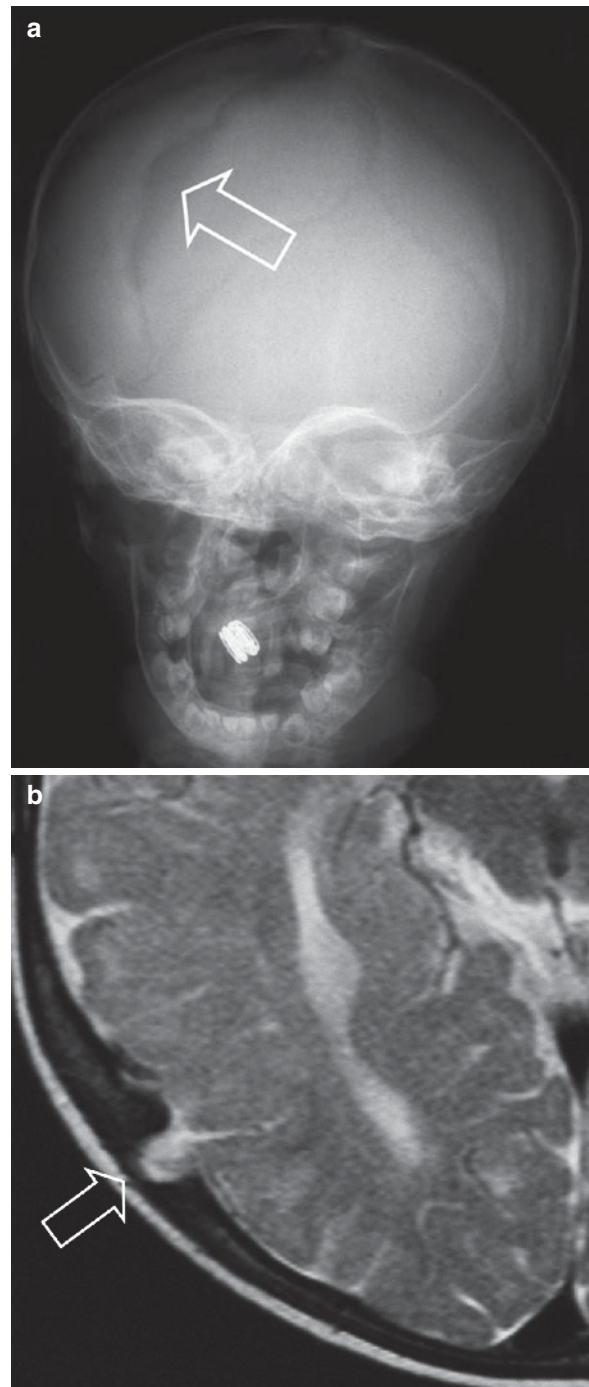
(a) One-year-old girl with a growing skull fracture. The skull view shows a diastatic fracture on the right dorsal parietal side. (b) Pre-operative MRI shows a dura defect and prolapsed meninges and brain tissue in the diastatic fracture (*open arrow*)
